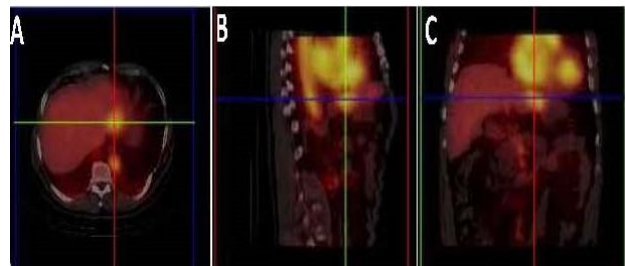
SPECT-TAC lesion located in the left hepatic lobe; a) Axial, b) sagittal and c) coronal planes.
